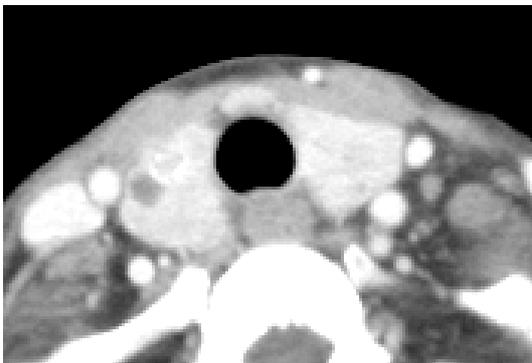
A contrast-enhanced computed tomography image of the thyroid gland. A low-density area was observed in the right lobe.
